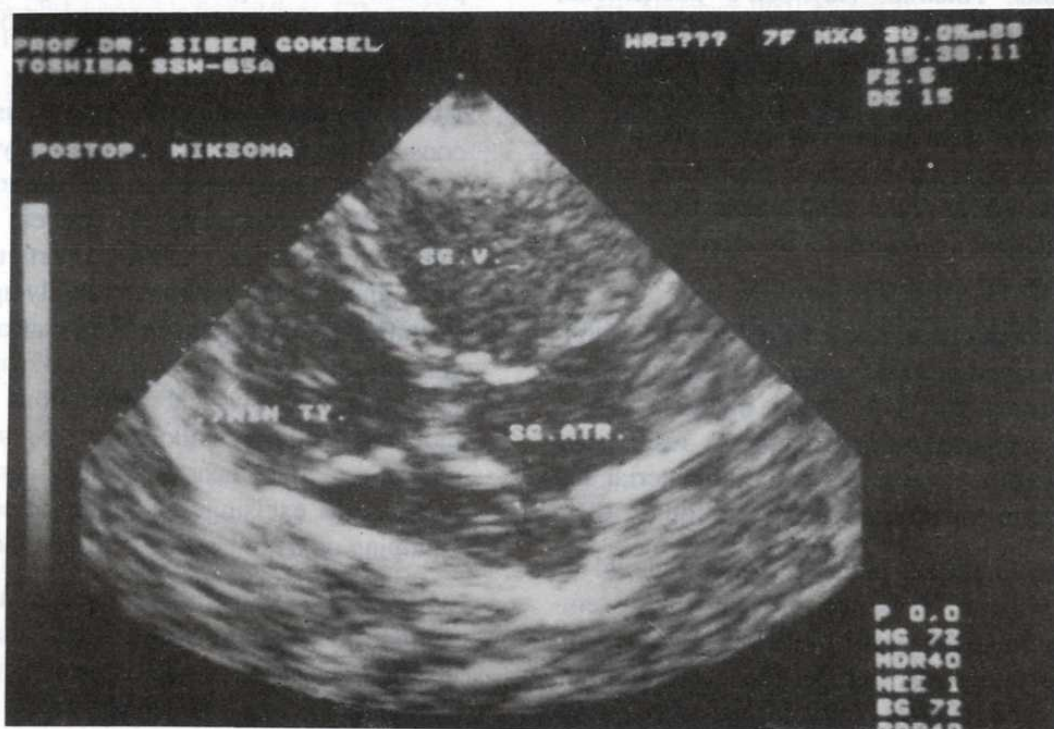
The postpreoperative doppler study of the patient
